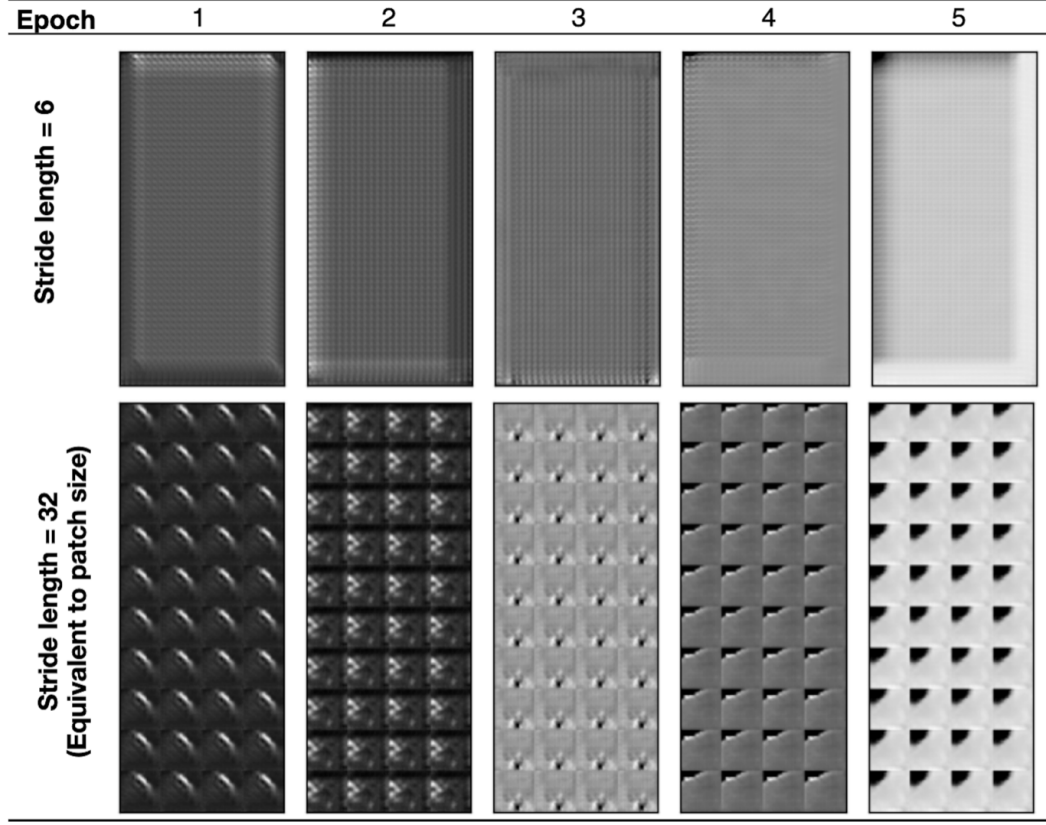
The conventional CycleGAN suffered from mode collapse when trained using the CT data. The top row shows the patched image reconstruction from the model at epochs 1-5, on one of the test CT volumes, with a stride of 6 (as used for CLADE). The bottom row shows that where there are no overlapping patches (i.e. stride length is equal to the patch size), then all patches remain identical, demonstrating mode collapse.
